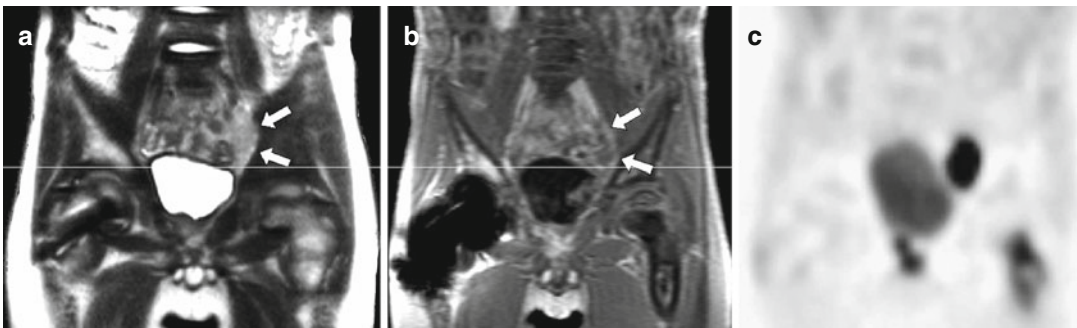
Recurrent tumor of a rhabdomyosarcoma lateral and superior to the urine bladder (arrows) in a 6-year-old boy. This recurrent lesion cannot be distinguished from the adjacent bowel neither in T2-weighted MRI (a) nor in the T1-weighted sequence after application of Gd-DTPA (b), thereby leading to a false-negative finding.
